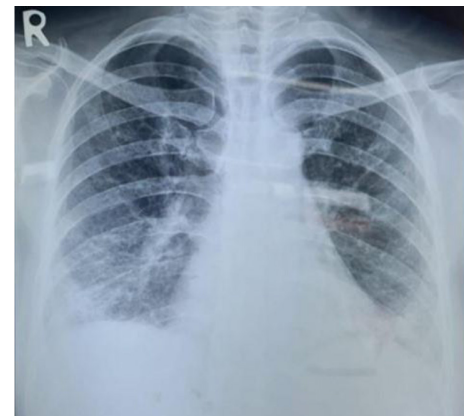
The chest x-ray showed bilateral parenchymal infiltrates in the lower lobes, indicating interstitial lung disease.
